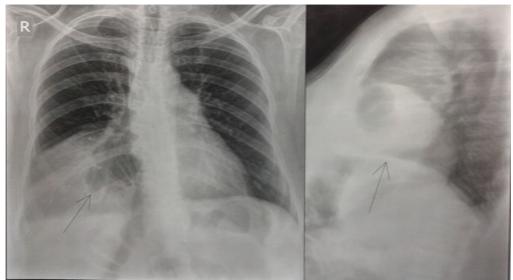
Preoperative chest X-ray, postero-anterior and lateral views, revealed bowel loops above the diaphragm.
